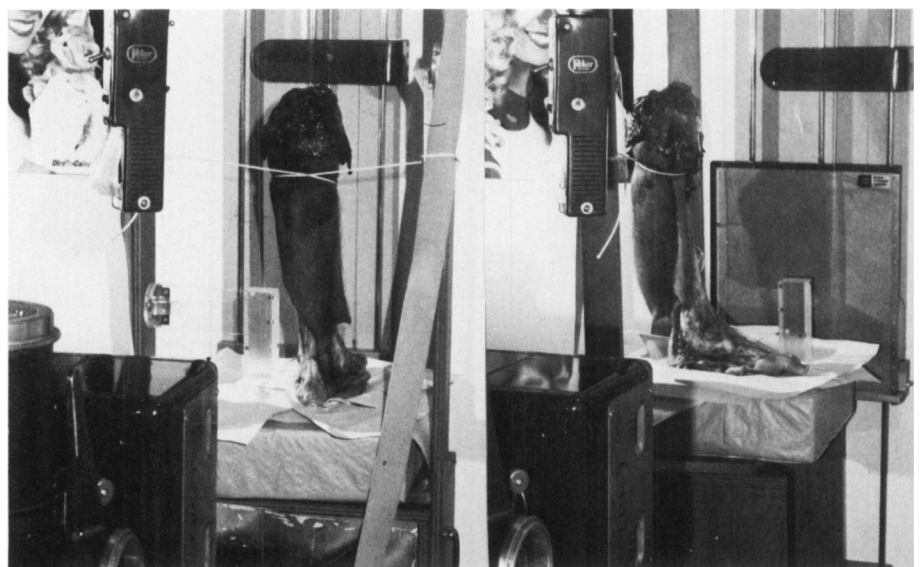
Lower limb on the rotating platform for (A) antero-posterior and (B) lateral normalized radiographs.
